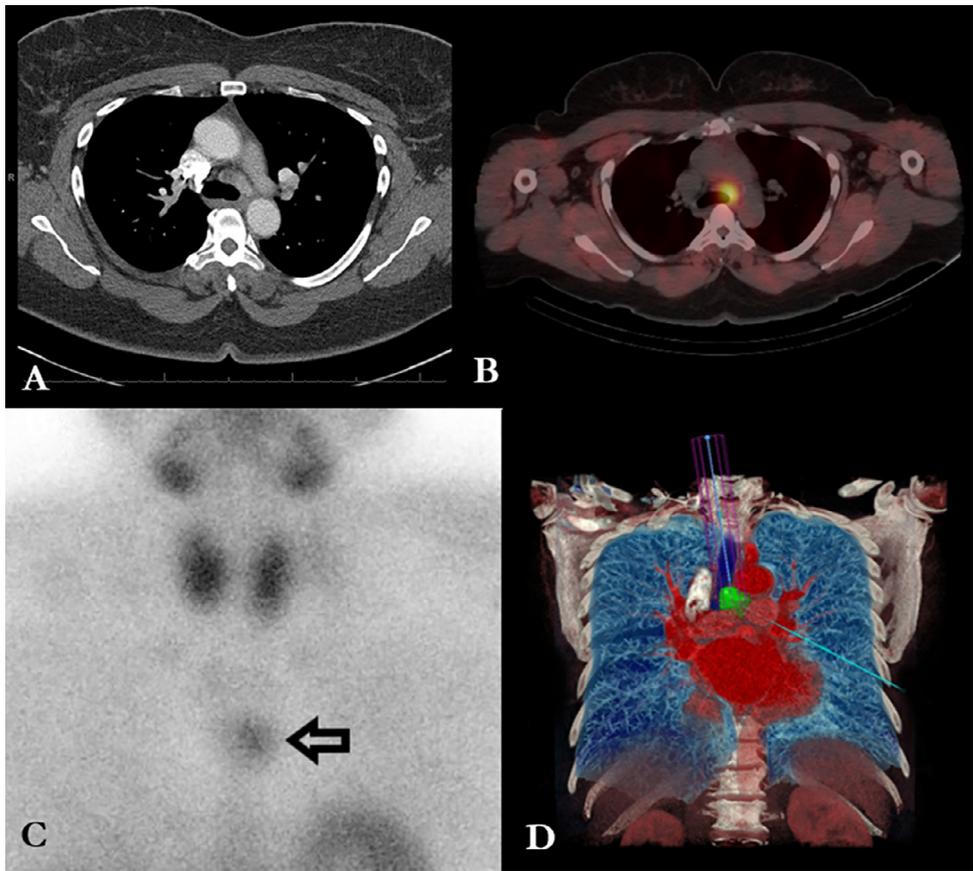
(A) Axial CT of the chest, heterogeneously enhancing left paratracheal mass, superior to the left main stem bronchus; (B) axial PET/CT, FDG-avid paratracheal mass; (C) parathyroid scan, intense uptake in the mediastinum (arrow); (D) Surgical Theater, coronal rendering of the chest (lesion is green lesion, between the arch of the aorta and left main pulmonary artery). (Color version of figure is available online at <http://www.semthorcardiovascsurg.com>.)
